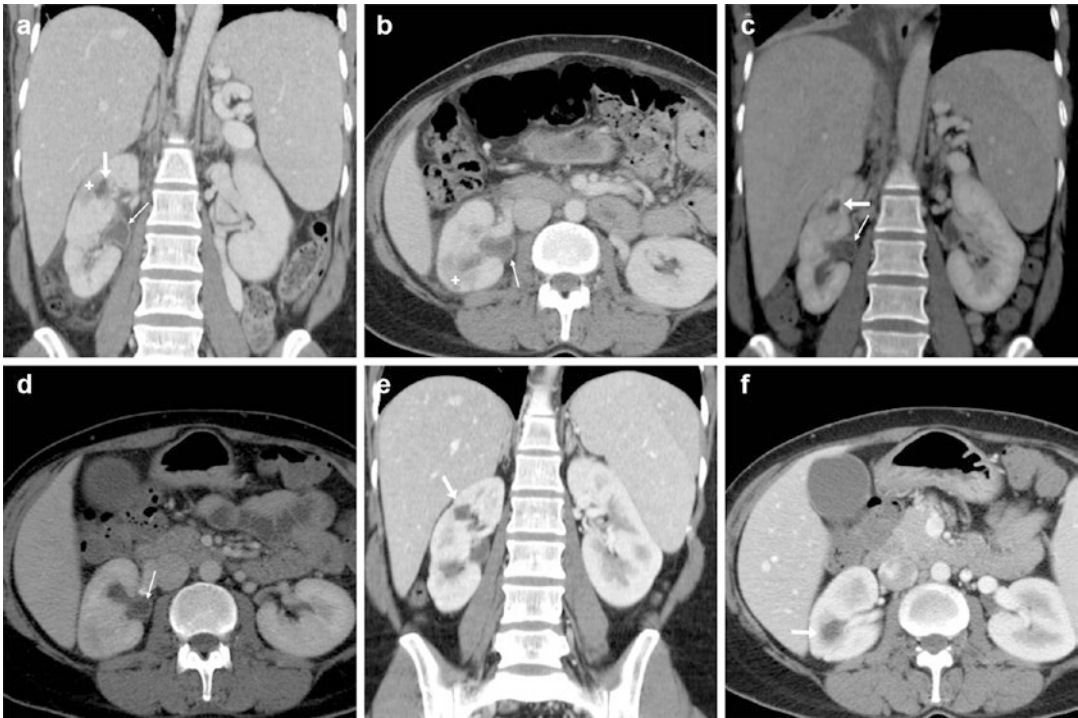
A 41-year-old female immigrant from the Middle East had history of renal colic 2 years ago. Currently attended at emergency department for abdominal and right flank pain associated with shivers, high fever and dysuria. Laboratory tests revealed leukocytosis and increased acute phase reactants. Urgent contrast-enhanced CT (a, b) showed mild, hyperenhancing thickening of the renal pelvis (thin arrows), calyceal dilatation (arrow) at the upper renal third, two wedge-shaped hypoperfused parenchymal areas (*), consistent with right acute pyelitis and pyelonephritis. Transferred to intensive care unit, she
